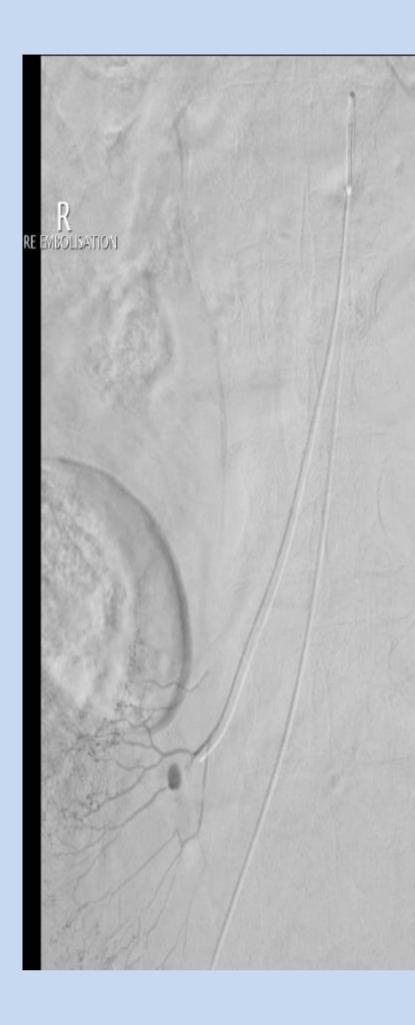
CT pre – embolization (left), during embolization (middle) post embolization (right)
